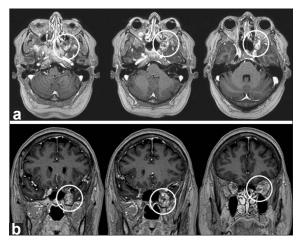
Contrast-enhanced (a) axial and (b) coronal MRI scans showing a lesion (white circle) involving the left orbital apex and located medial to the optic nerve. The lesion also involves the pterygoid fossa, the middle fossa, the maxillary sinus and the sphenoid sinus
